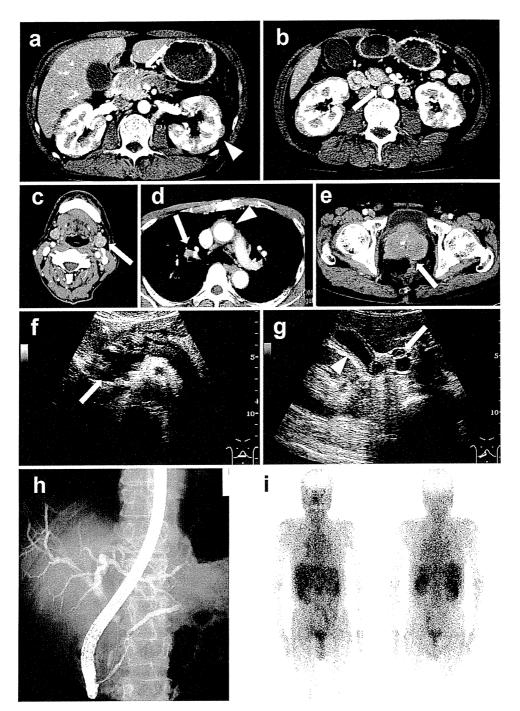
The multiple inflammatory lesions of IgG4-related disease found in our case. Contrast-enhanced computed tomography (CT) showed diffuse enlargement of the pancreas with tumorous changes in the head (a, white arrow), multiple, small, low-attenuation lesions with mild swelling in the bilateral kidneys (a, white arrowhead) and homogeneous thickness in the arterial walls of the abdominal aorta (b, white arrow). Swelling of the submandibular glands (c, white arrows), swelling of the pulmonary hilar lymph nodes (d, white arrow), wall thickness in the ascending aorta (d, white arrowhead) and swelling of the prostate (e, white arrow) were marked. Ultrasonography (US) revealed tumorous swelling in the pancreatic head (f, white arrow), mild dilatation of the pancreatic duct on the tail side and diffuse thickening of the bile duct (g, white arrow) and gall bladder walls (g, white arrowhead). Endoscopic retrograde cholangiopancreatography (ERCP) revealed an irregular surface pattern in the pancreatic and common bile duct walls. A stricture was observed on the pancreatic head side, and mild dilatation was observed in the pancreatic tail and peripheral bile duct (h). Gallium-scintigraphy revealed accumulation in the periorbital tissues, salivary glands, pulmonary hilar lymph nodes, kidneys, prostate and retroperitoneum (i).
